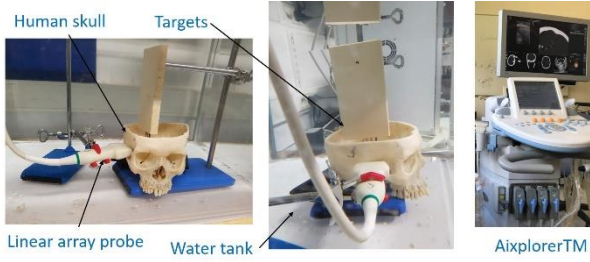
Description of the acquisition set-up. The fusion device to mix ultrasound images and CT scan in real-time is presented on the AixplorerTM device screen.
